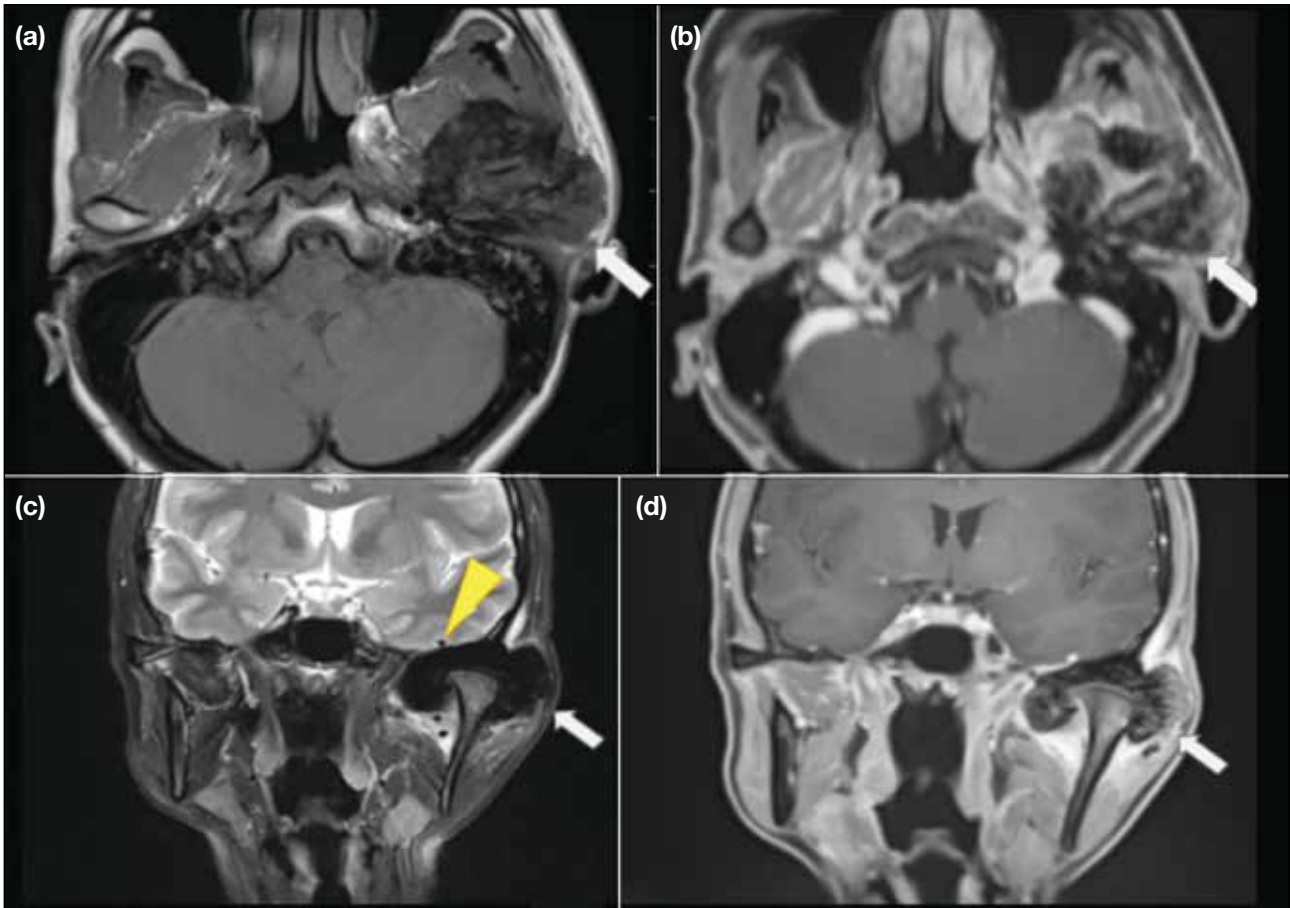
(a) Axial T1-weighted, (b) axial T1-weighted post-gadolinium contrast enhanced, (c) coronal T2-weighted, and (d) coronal T1-weighted post-gadolinium contrast enhanced magnetic resonance images show the tumour (arrows) at the left temporomandibular joint, which is markedly T1- and T2-weighted hypointense with contrast enhancement mainly over the periphery. There is erosion of the base of the temporal fossa with the tumour abutting a cortical vessel (yellow arrowhead in [c]).
